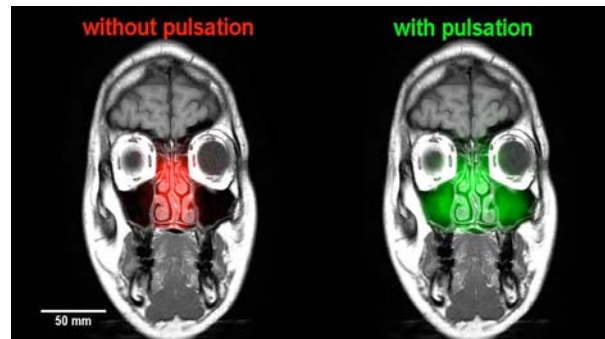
Lateral MRI slice showing marker gas distribution without pulsation (left image) and with pulsation (right image) within the nasal cavity and the maxillary sinuses (courtesy of PARI).
